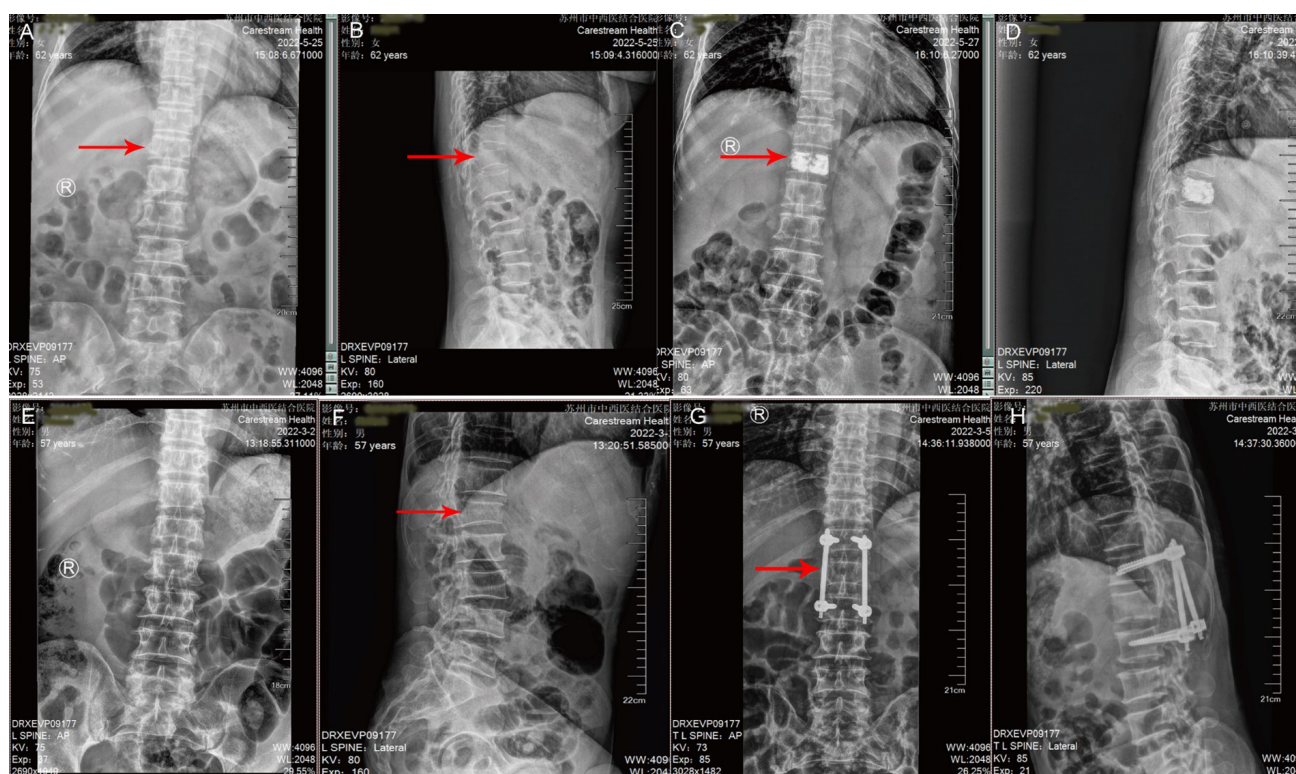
Representative X-ray images of patients treated with PKP (A–D) and PPSF (E–H). X-ray images before and 1 day after surgery are shown. Red arrows: Injured vertebral body. (A,B) Preoperative X-ray image showing T12 vertebral compression fracture. (C,D) Postoperative X-ray images showing good fracture healing, proper position of bone cement, no loosening or displacement of bone cement, and minimal bone cement leakage. (E,F) Preoperative X-ray views showing L1 vertebral compression fracture. (G,H) Postoperative X-ray images showing good fracture reduction, proper placement of pedicle screws, appropriate length and position of pedicle screws, and no loosening or displacement of bone cement. Injured vertebral body is indicated by red arrow. PKP, percutaneous kyphoplasty; PPSF, percutaneous pedicle screw fixation.
